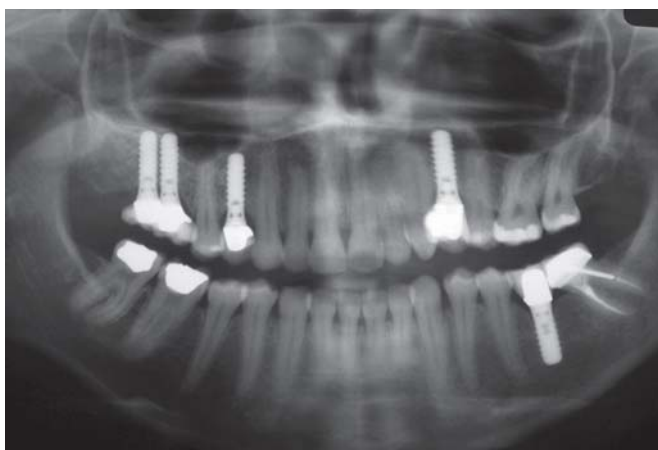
Orthopantomograph showing a stable clinical situation 2 years after treatment. A dome-shaped structure was apparent at maxillary right molars areas, indicating a substantial increase in bone volume. The dome was surrounded by a new cortical bone plate
